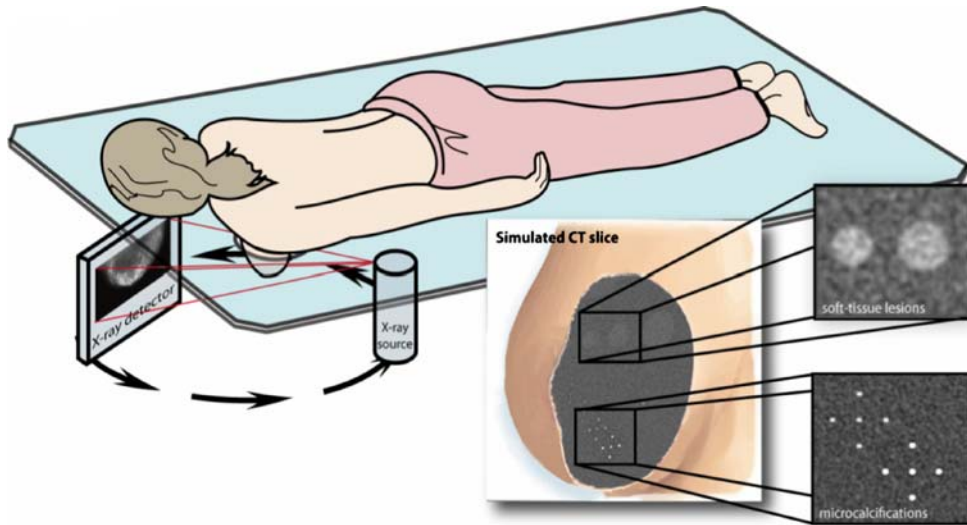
In dedicated breast CT, the patient will be scanned in prone position with only one breast exposed at a time with low X-ray dose. Calculations and preliminary measurements indicate that we will be able to display microcalcifications as well as or even better than in standard mammography. Soft-tissue lesions which in mammography are often obscured by overlaying tissue will be displayed clearly without an increase in dose at decreased spatial resolution. Note: The two separate inserted displays of soft tissue lesions and of microcalcifications are derived from the same, single measurement by different processing.
